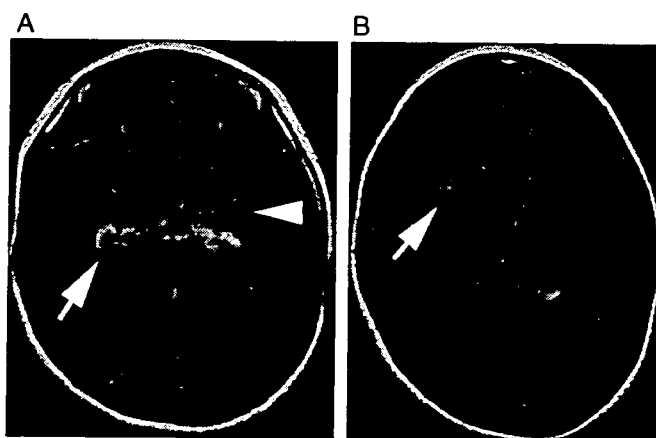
Axial fluid-attenuated inversion recovery (FLAIR) images (TR/TE/TI 6000/120/2100 ms), using a 1.5 T imager, on day 27 showed high signal lesions in both hippocampi (arrow), amygdalae (arrowhead) (A), and claustrum (arrow) (B).
